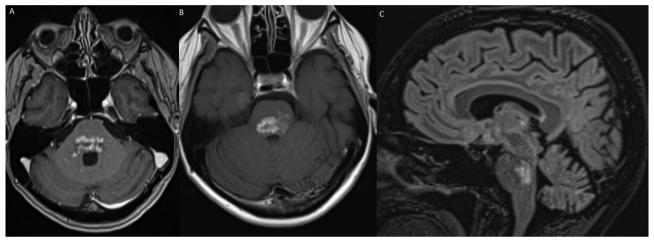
The follow-up brain MRI: T1-weighted post-gadolinium axial scan (A, B), T2-weighted sagittal scan (C)
